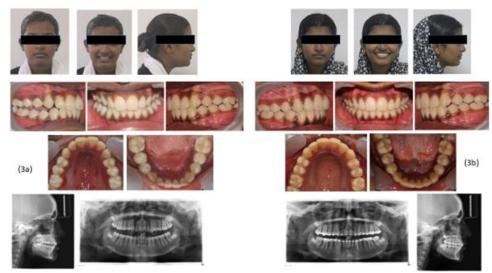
(a) Post- functional extraoral and intraoral photographs and radiographs. (b) Post - treatment extraoral and intraoral photographs and radiographs.
